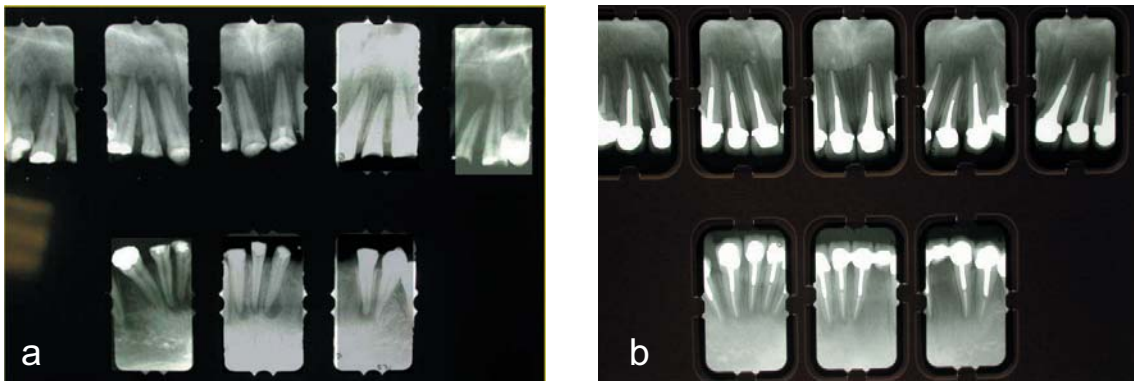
a&b. Radiographs of upper and lower teeth before and after treatment.
